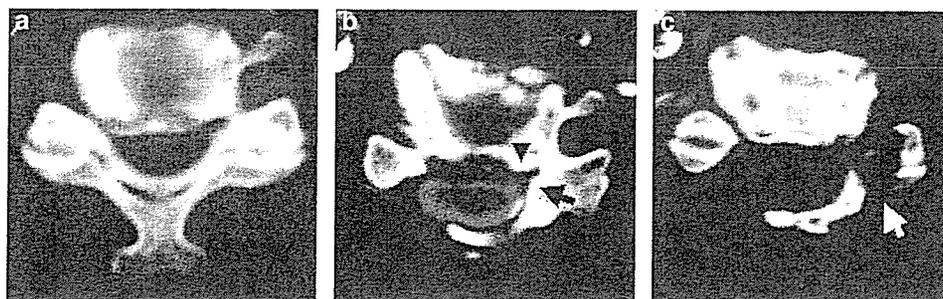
CT findings at C4–C5 level in Case 1. (a) CT myelogram before first operation. (b) CT myelogram 5 years after first operation. (c) CT 1 month after second operation. CT myelography revealed posterior spur formation (arrowhead) and hypertrophic facet joint (arrow) at the hinge side 5 years after the first operation. Posterior foraminotomy was performed on the left side (white arrow)
